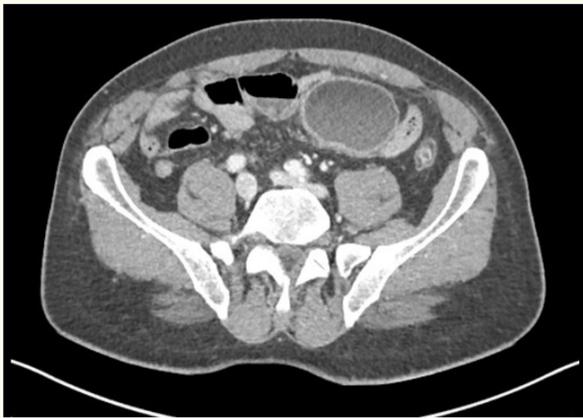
Coronal abdominal CT scan who reveal the close contact between the bowel loop and the mesenteric cyst.
